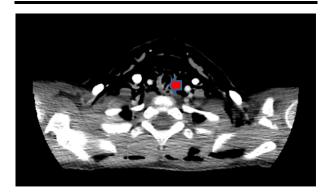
Axial CT scan of neck with contrast, which was suspicious for a tear through the posterior wall of the trachea into the anterior wall of esophagus. This was confirmed intraoperatively by endoscopy, noted to be 4 cm in length. Diffuse cervical emphysema was also present.
